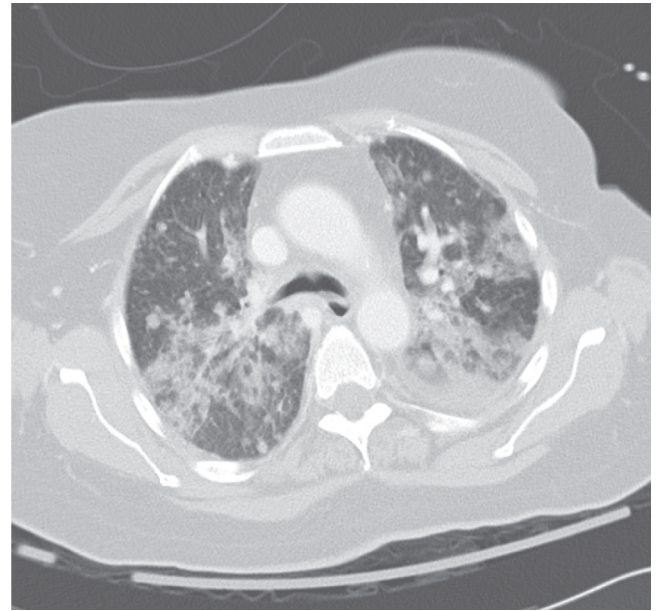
■ Computed tomography of the chest in a patient with a history of breast cancer and rapidly progressive bilateral ground-glass opacities. Lung biopsy revealed metastatic adenocarcinoma. There was a desmoplastic reaction around sites of tumor leading to focal areas of interstitial fibrosis as well.
